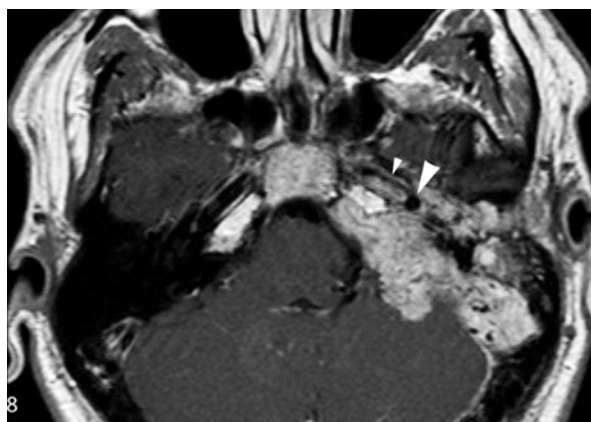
MRI with gadolinium (axial view) of a case of right C3 TJP at the level of the horizontal segment (*small arrow head*) of the internal carotid artery. Note the encasement of the vertical segment (*big arrow head*) of the artery
